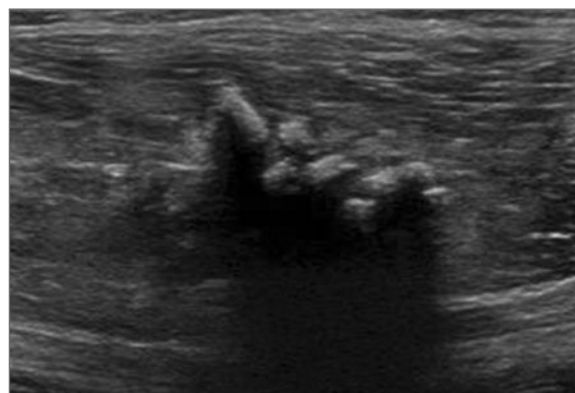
Longitudinal image of the bicep femoris muscle. There are irregular hyperechoic foci within the muscle belly with loss of normal surrounding muscle architecture. The foci itself demonstrate posterior shadowing. The patient was a 32-year-old footballer who described a hamstring strain several months previously. Rehabilitation had not fully resolved symptoms and an ultrasound was performed. The image is in keeping with a myositis ossificans of the bicep femoris muscle.
